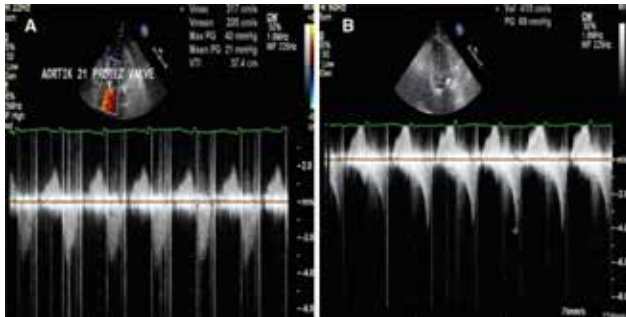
(A) CW doppler study shows peak and mean gradients across the prosthetic aortic valve. (B) CW doppler study of LVOT shows a peak gradient of 69 mm Hg with the Valsalva maneuver.
